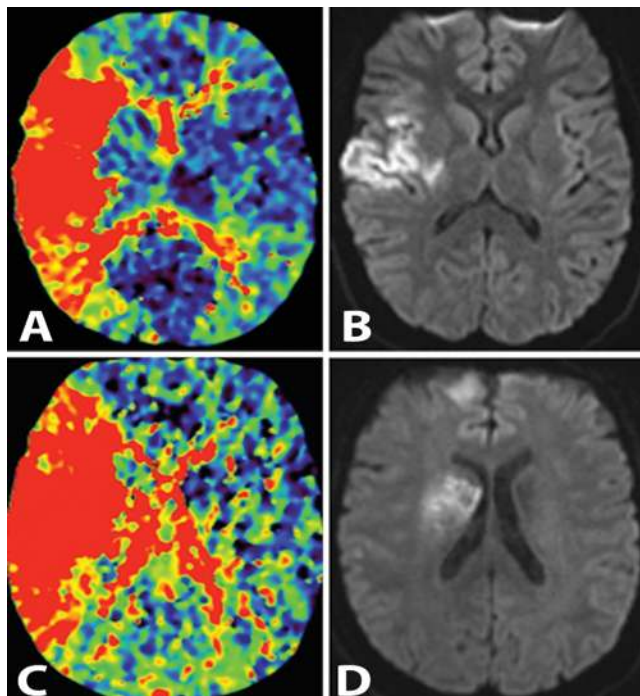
Case 1. A: Initial CT perfusion study showing TTP prior to balloon angioplasty and thrombectomy. B: Diffusion-weighted MR image obtained after endovascular intervention. Preprocedure TTP (A) shows a large area of ischemia in the entire right MCA territory compared with smaller final infarct size (B) postprocedure. Case 2. C: Initial CT perfusion study showing TTP. D: Diffusion-weighted MR image acquired after the endovascular intervention. The TTP shows a larger area of ischemia in the right MCA territory preprocedure (C) compared with the final infarct size (D) postprocedure.
